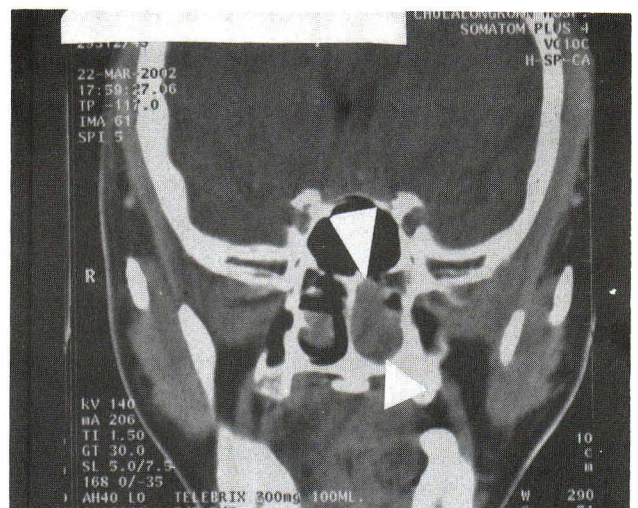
Post contrast coronal CT scan through the anterior part of sphenoid sinus shows a soft tissue mass (arrowed) occupying in the entire left nasal cavity.
